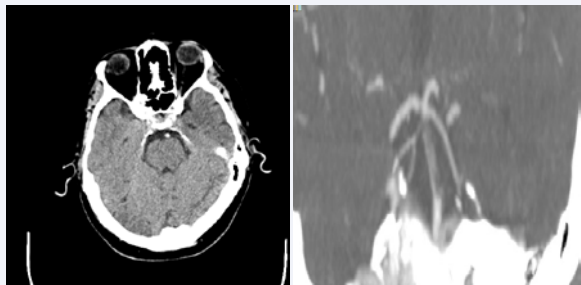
Native CT (A) of the brain and CT angiography (B) during initial workup in the regional hospital showing basilar artery occlusion.
